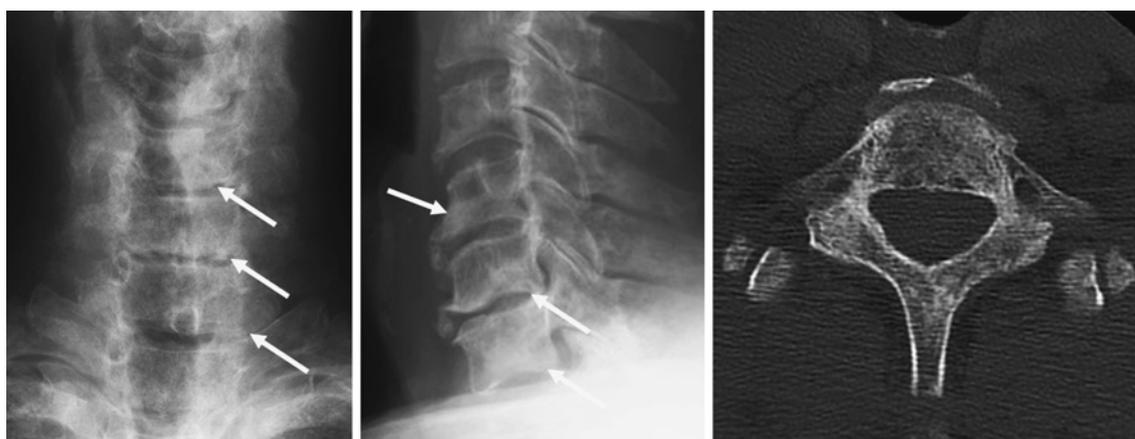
Radiographic imaging of a 69-year-old man with multiple cervical vertebra metastases of prostate cancer. Radiographs show an abnormal osteoblastic change (arrow). CT shows an osteoblastic change in the whole 7th cervical vertebra.
